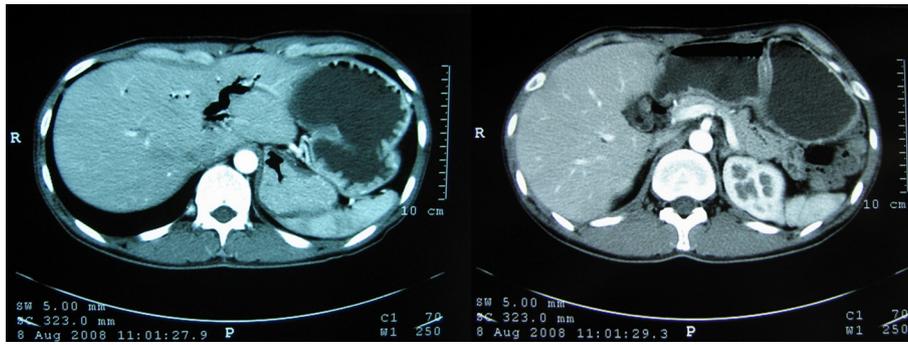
Abdominal computed tomography. Peumobilia in the intrahepatic bile duct (left) and dilatation of the stomach (right) was found.
